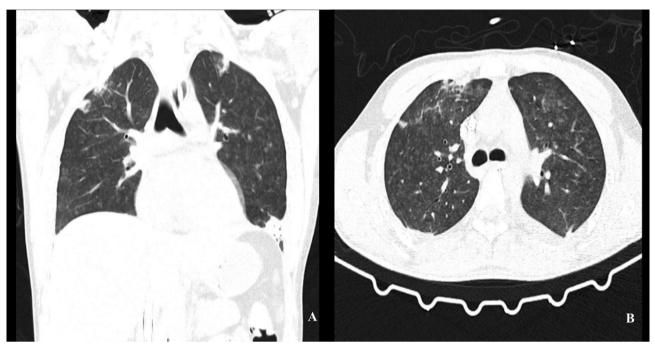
Angio-CT scan showing consolidation with atelectasis centered in the apical segments of the lungs.
